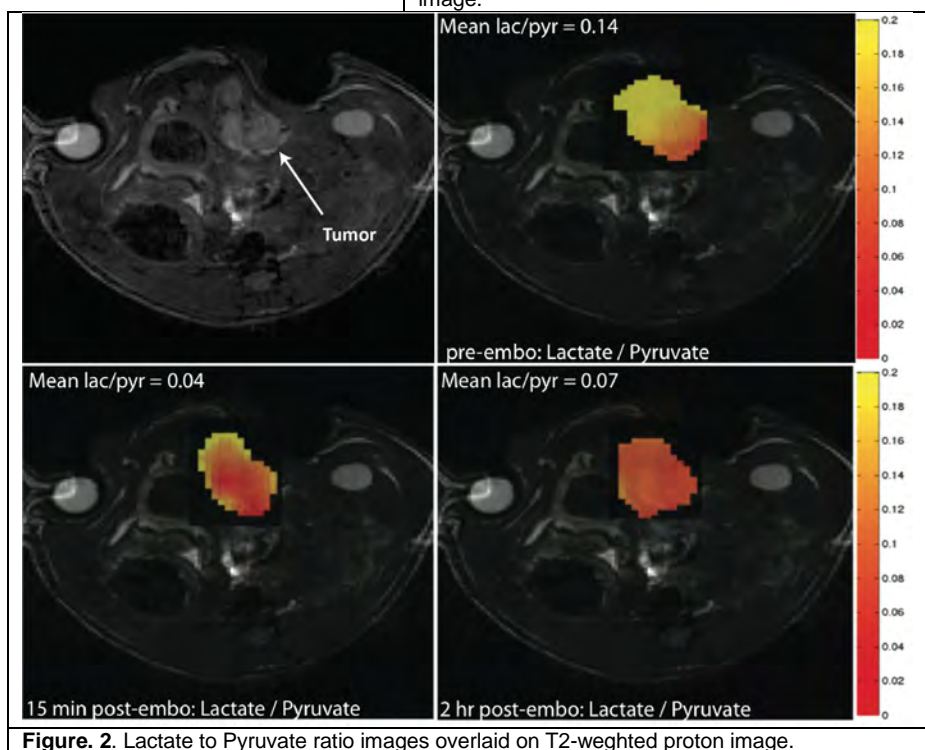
Lactate to Pyruvate ratio images overlaid on T2-weighted proton image.
